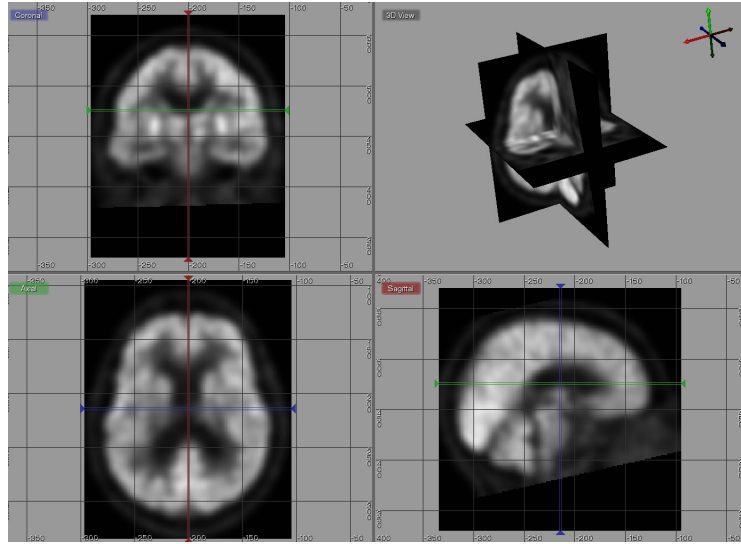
Example of result registration between PET and MRI using FLIRT.
